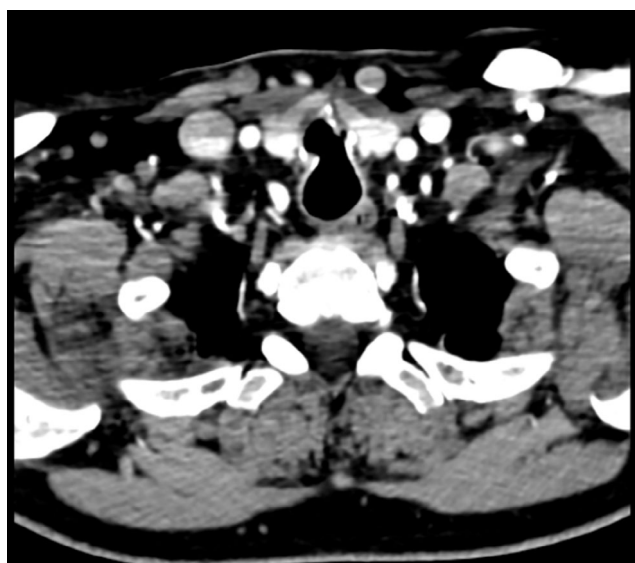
Preoperative computed tomography (CT) scan showing airways narrowing.
